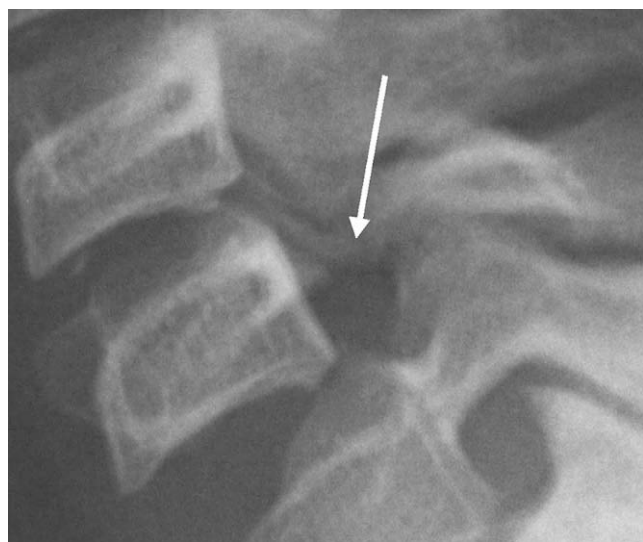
Lateral X-rays of the sixth cervical vertebra showing the hypoplasia and the thin residual osseous bridge in the area of the lysis (arrow).
